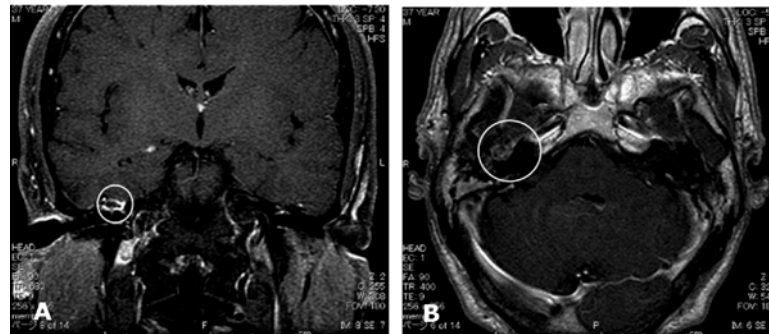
MRI findings with contrast enhancement. a: coronal view showing the lesion (open circle); b: axial view showing the lesion (open circle).
